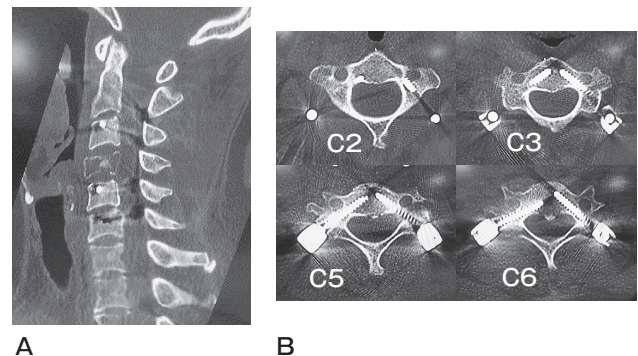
Postoperative CT. All pedicle screws were inserted at the correct position as shown by CT.
